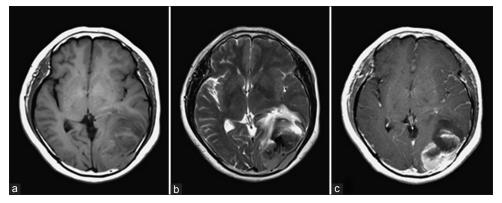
Magnetic resonance imaging. (a) T1-weighted image. Iso-intense signal at the peripheral area of the mass lesion. Iso- to mildly hypo-intense signal at the central area of mass lesion. (b) T2-weighted image. Iso-intense signal at the peripheral area of the mass lesion. Hypointense signal at the central area of mass lesion. (c) T1-weighted image with gadolinium enhancement. Gadolinium enhancement at the peripheral area of the mass lesion
